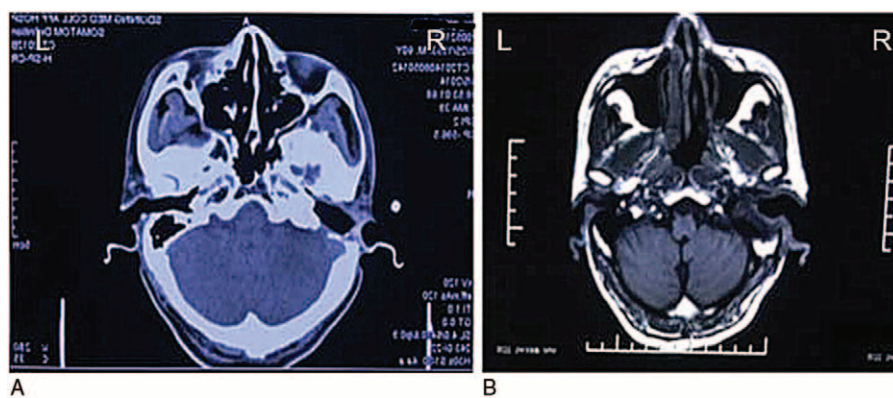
(A) Computed tomography (CT) of the middle ear and mastoid scan showing postoperative changes in the right middle ear carcinoma. (B) Magnetic resonance imaging (MRI) of middle ear and mastoid showing postoperative changes of the right middle ear carcinoma.
